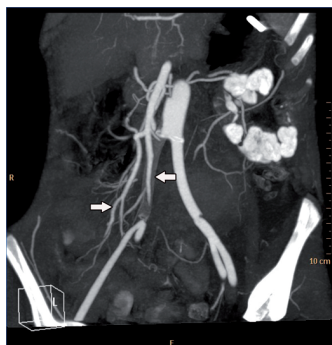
Post-operation CT-angio, showing the occluded right limb of the graft (arrows) with large collateral filling of the right common iliac artery, external iliac artery, and internal iliac artery.
